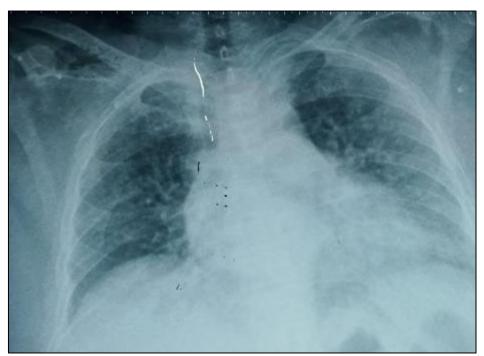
Frontal X-ray of the lung diffuse interstitial syndrome, blunted cds, CMG
